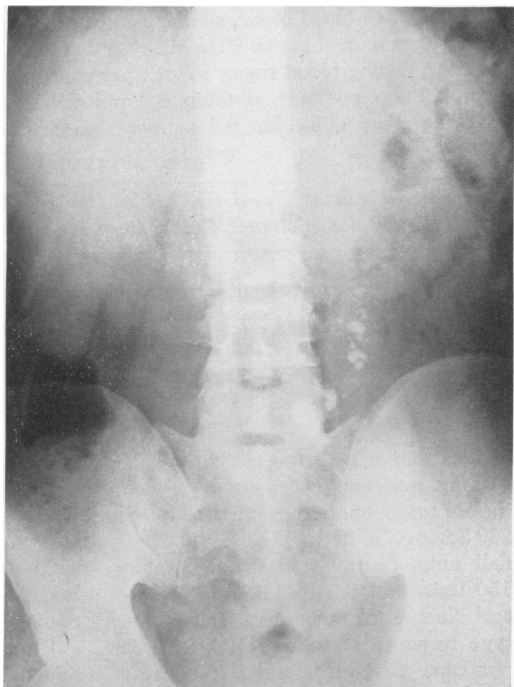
Roentgenogram of abdomen showing calcification of pancreas (Case 1).
